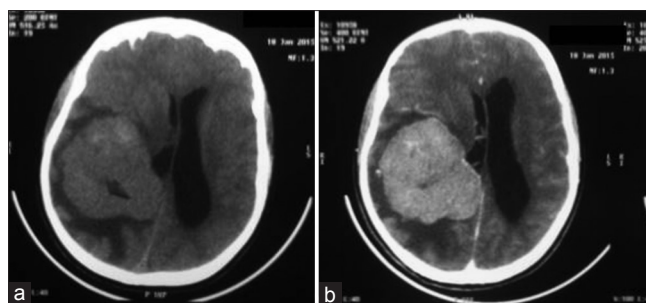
Computed tomography scan showing huge hypodense (a) and hyperdense (b) paraventricular tumor
